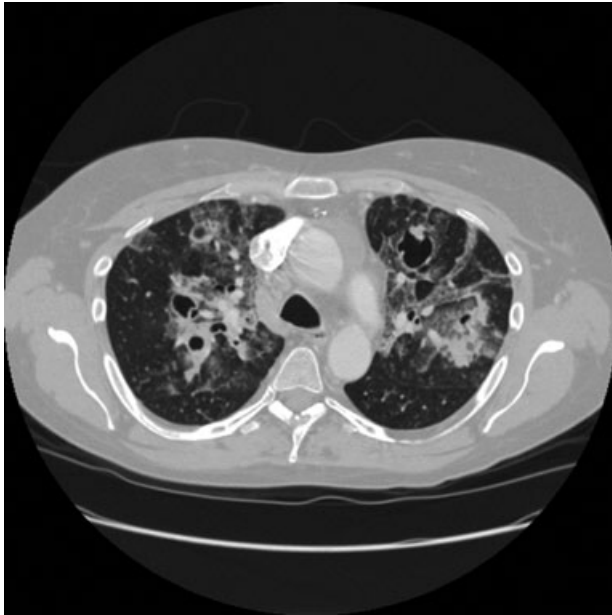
CT of chest revealing cavities, bronchiectatic changes, and extensive consolidation.
